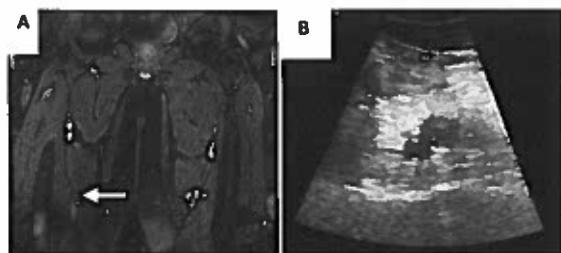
DVT shown by (A) 3D T1 FFE steady state / VIBE MRI sequences and correlated by (B) Doppler echography.
